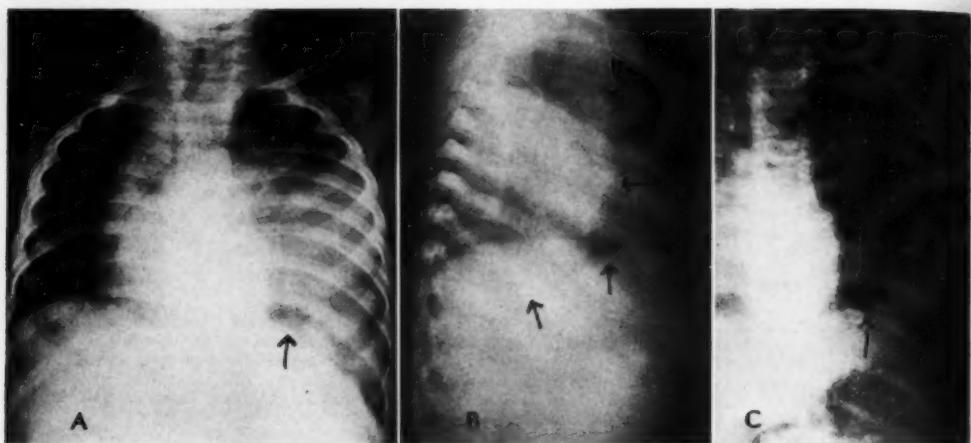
Case 4: A. Postero-anterior roentgenogram made three weeks after Fig. 4C (Feb. 3, 1942). Note pockets largely filled with fluid except for one small cyst in the inferior portion containing only gas.
